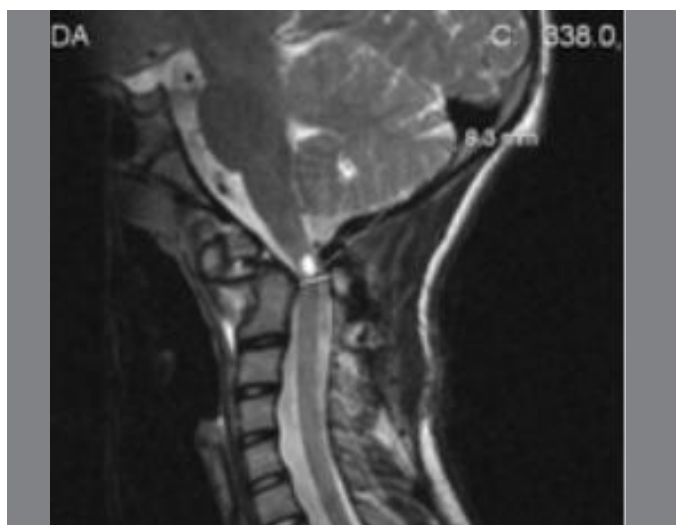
In the MRI the SAC is 8,3mm.
